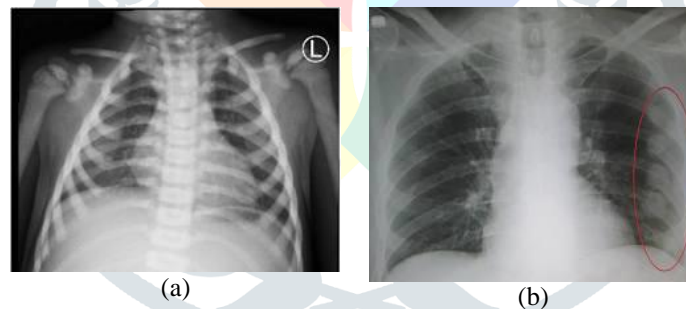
(a) This rib X-ray exhibits normal bone density and structure, with well-defined cortical margins and no fractures, (b) This rib X-ray shows a fracture in the fifth rib, indicated by a disruption in the continuity of the bone cortex.
